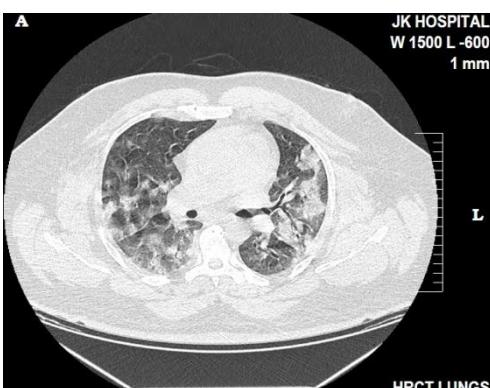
HRCT of young patient age between 36-40 year showing multiple patches of consolidation and septal thickening giving crazy paving appearance. CT severity score; 24-26 (Severe lung involvement).
